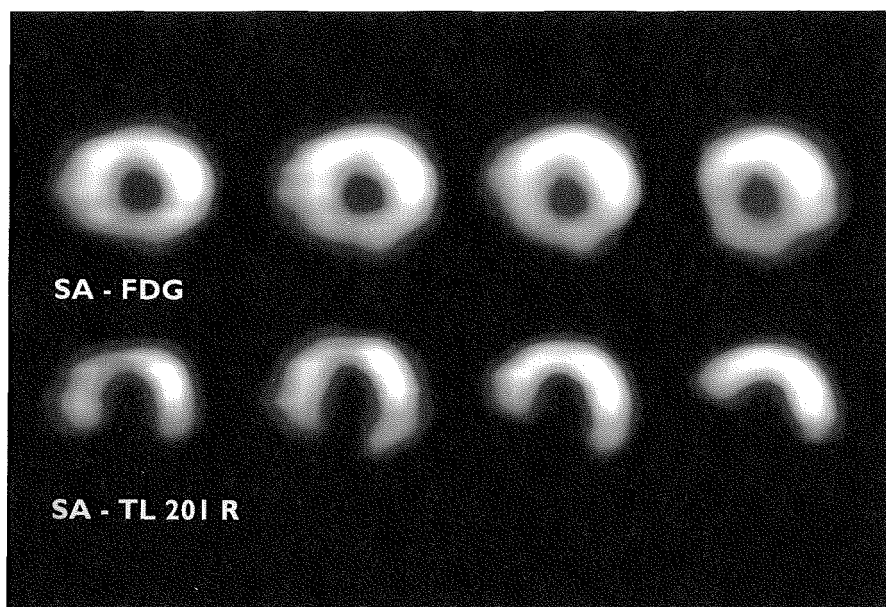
Corresponding series of short axis FDG- (top) and ^{201}Tl slices (bottom) demonstrating a perfusion-metabolism mismatch in the infero-septal region.
